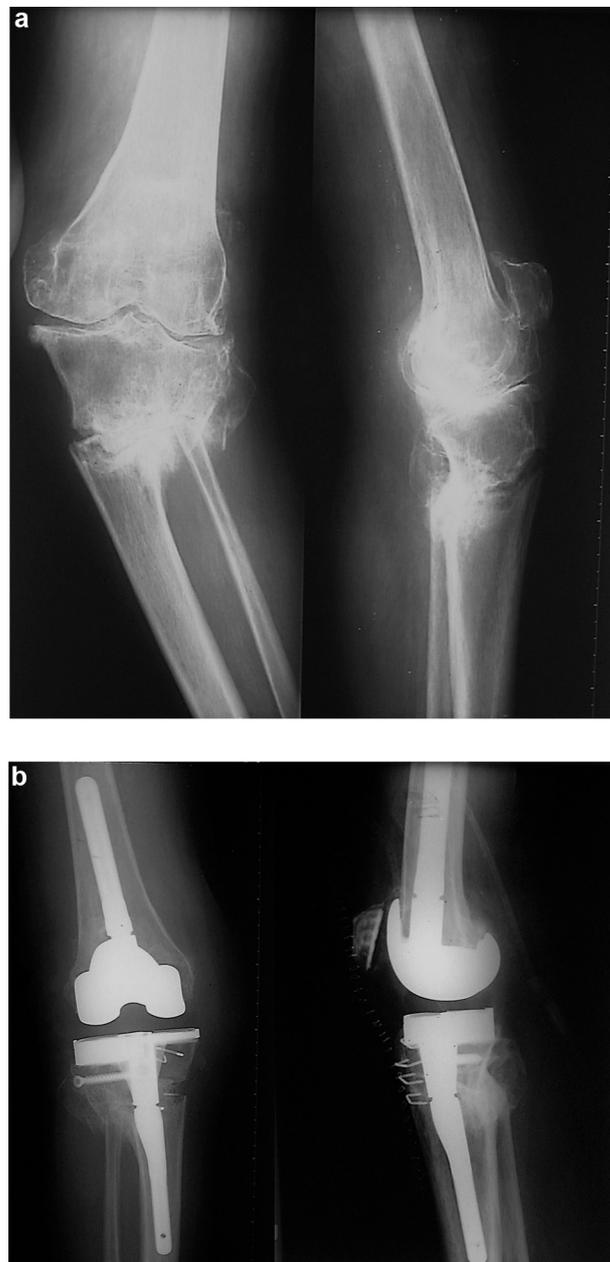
a: knees #13 and #14, 60-year-old male with knee osteoarthritis complicating bilateral constitutional tibial valgus deformity; b: long-leg radiograph before surgery; c: total knee arthroplasty and bilateral tibial medial closing-wedge osteotomy; d: long-leg weight-bearing radiograph after surgery on the second knee showing a very good outcome.
